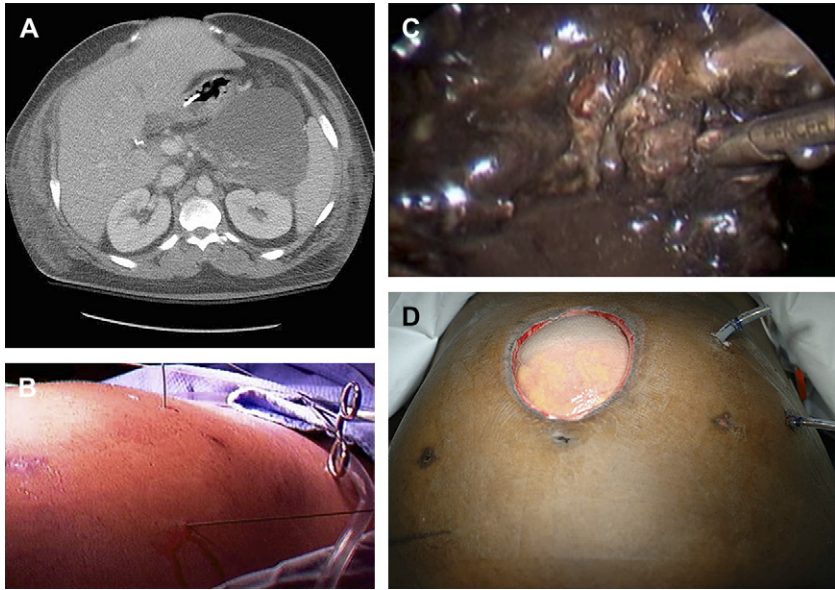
(A) Pancreatic necrosis in a patient who required an emergency bedside celiotomy for decompression of an acute abdominal compartment syndrome. His abdomen was then closed using absorbable mesh. A few weeks later he developed persistent fevers and fine-needle aspiration of this large area of fluid and necrotic debris confirmed the presence of infection. As seen in this image, his liver is adherent to the margins of his abdominal wall defect, impeding open debridement and drainage of the infected necrosis. (B) Under ultrasound guidance, two guidewires have been placed into the areas of necrosis. Introducer assemblies consisting of a dilator and peel-away sheath are then advanced over the guidewires, and through the sheath a 5-mm port is then inserted. In this figure, the dilator has been advanced over the guidewire in the epigastrium. (C) With two ports placed, necrotic tissue in the lesser sac cavity is debrided using a grasping instrument. (D) On completion of the necrosectomy, the ports are replaced with large drains. In this patient, intermediate-sized chest tubes were used, because these provided effective drainage and permitted easy reinsertion of ports if further debridement was necessary.
